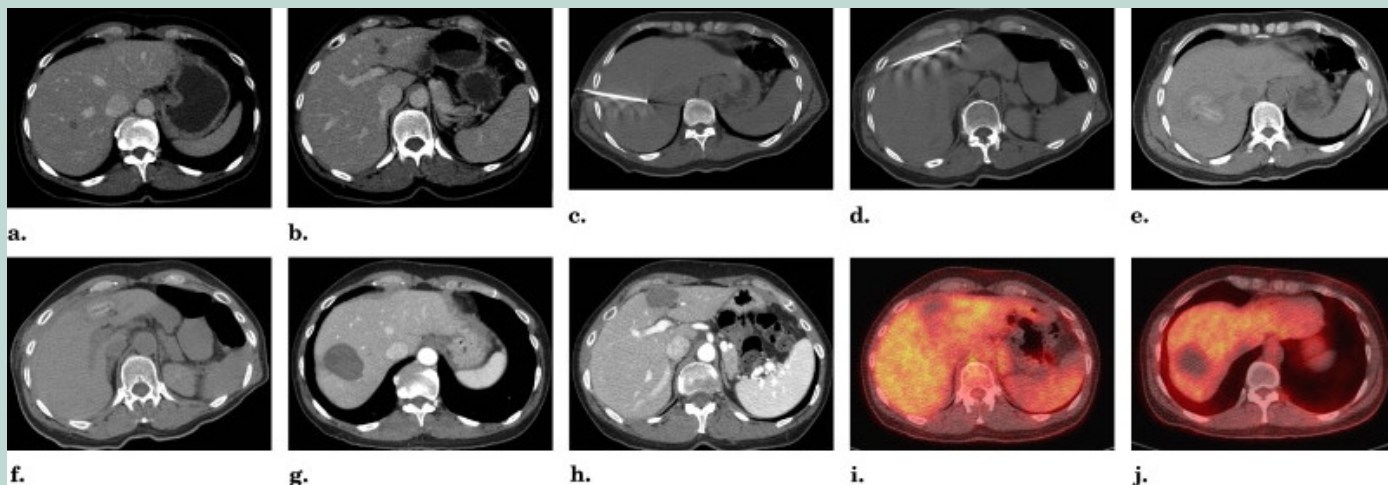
(a,b) Fifty-year-old woman with adenocarcinoma of the sigmoid colon presents with two hepatic metastasis. (c,d) Both lesions were treated with a cluster RF ablation electrode during same session. Immediate postprocedural imaging shows the expected internal hyperattenuation from denatured proteins. (e,f) The area of ablation is much larger than the original metastasis. (g-j) One-year follow-up shows expected hypoattenuating region encompassing the prior metastatic focus with at least 1 cm margin and no FDG avidity, consistent complete treatment. Source: *Journal of Vascular and Interventional Radiology* 2010; 21:S214-S222 (DOI:10.1016/j.jvir.2010.01.046)
